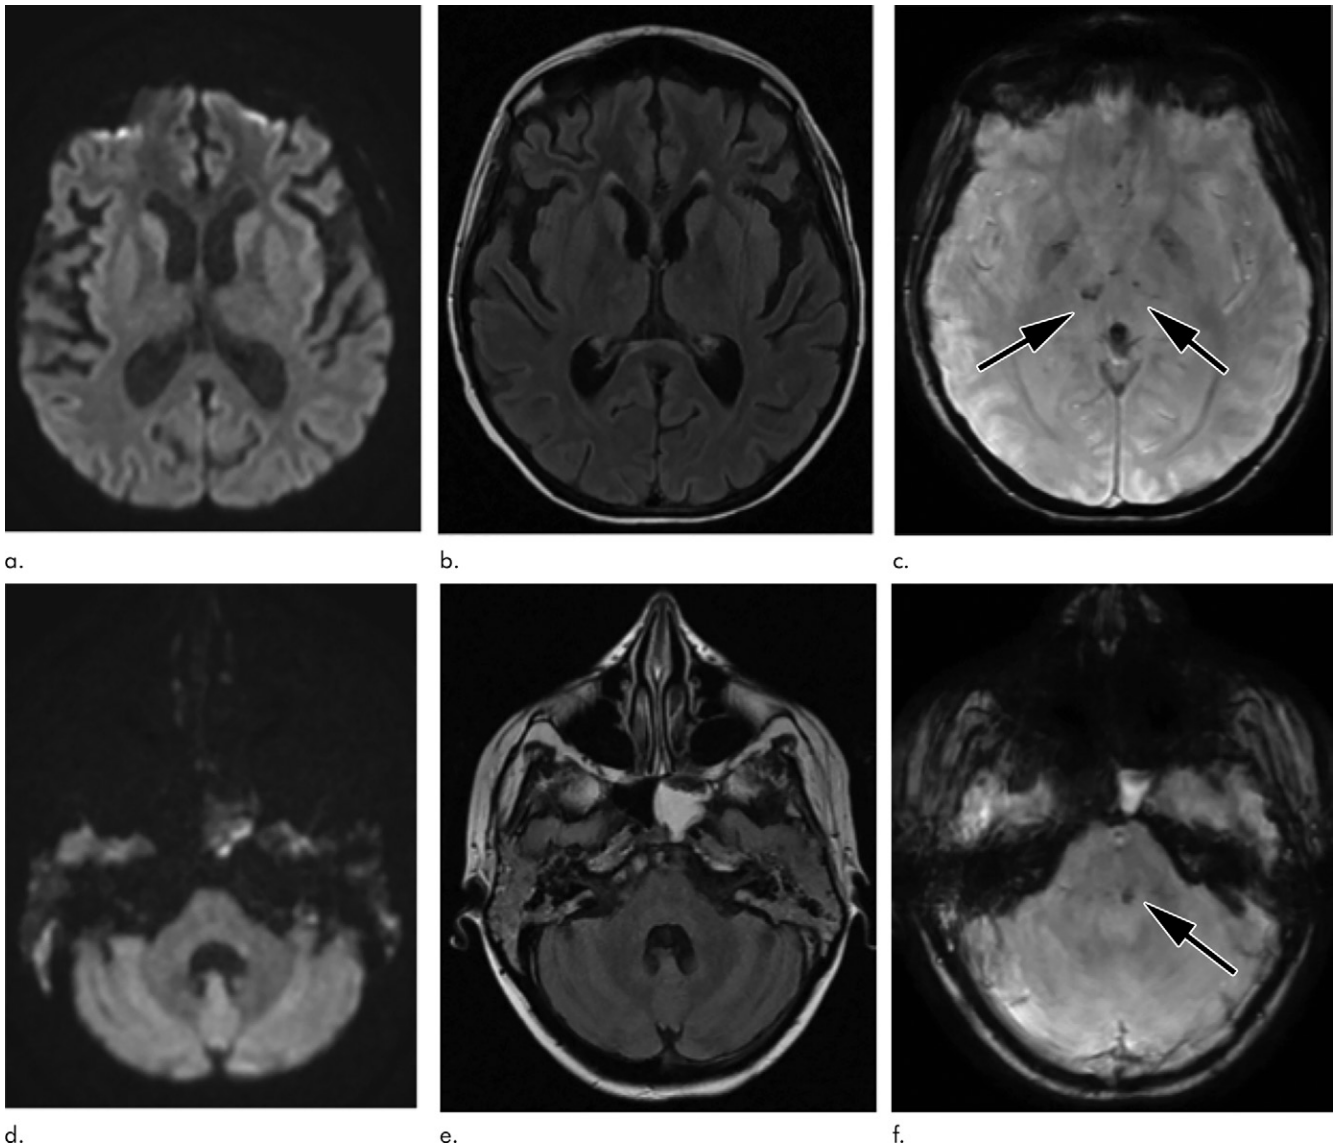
Images obtained 1 month after presentation at the level of the (a, b, c) thalami and (d, e, f) pons. (a, d) Axial diffusion-weighted MRI scans (repetition time msec/echo time msec, 9000/97; b value = 1000 sec/mm²) show resolution of the prior diffusion restriction involving the thalami and pons. (b, e) Axial T2 fluid-attenuated inversion recovery MRI scans (repetition time msec/echo time msec/inversion time msec, 9605/127/2500) show resolution of the prior confluent T2 hyperintensity throughout the bilateral thalami, pons, and middle cerebellar peduncles. (c, f) Axial susceptibility-weighted MRI scans (74/46) show persistent punctate hypointensity (arrows) in the bilateral thalami and pons.
